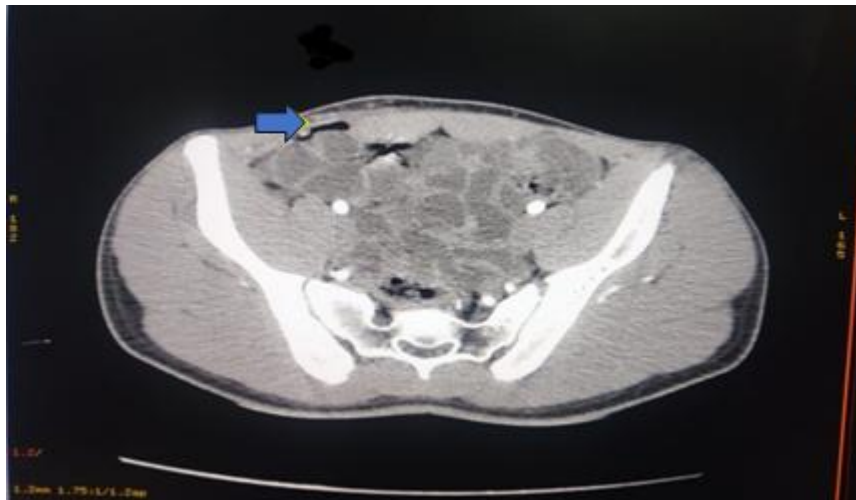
CT scan showing the defect
